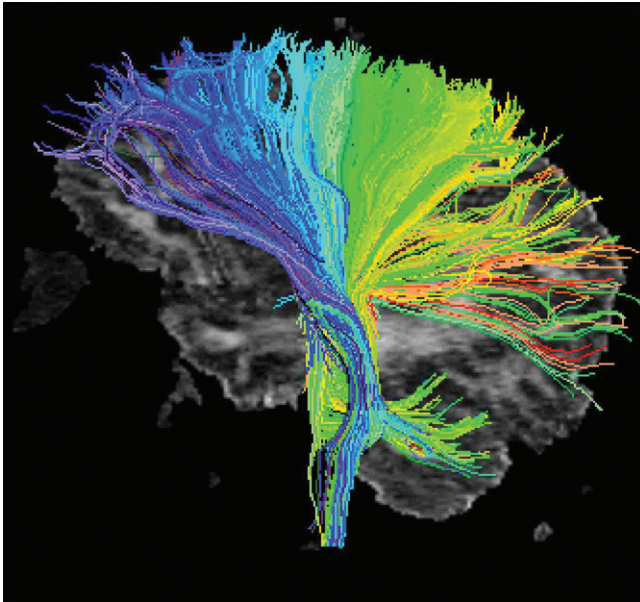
A fountain-like image of the white fiber tracts. This beautiful spray of neuronal tracts results from an MRI imaging technique called diffusion tensor imaging (DTI), which allows us to view the white (myelinated) fiber tracts. These are the vertical traffic arteries that flow from the cortex (especially frontal regions, shown in blue), down the spinal cord, and upward from the spinal cord to the rear half of the cortex, shown in yellow and green. Most of the volume of cortex is taken up by these massive fiber tracts. Source: Maria Lazar, with permission.
